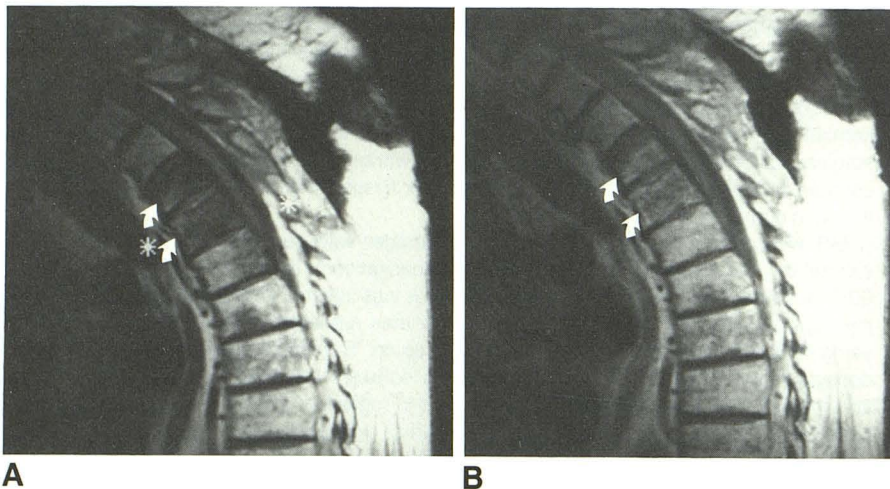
A and B, Vertebral metastatic prostatic carcinoma (arrows) in pre- (A) and post- (B) Gd-DTPA spin-echo 800/20/2 MR images. Both metastatic tumors in the study were more evident in unenhanced images.
